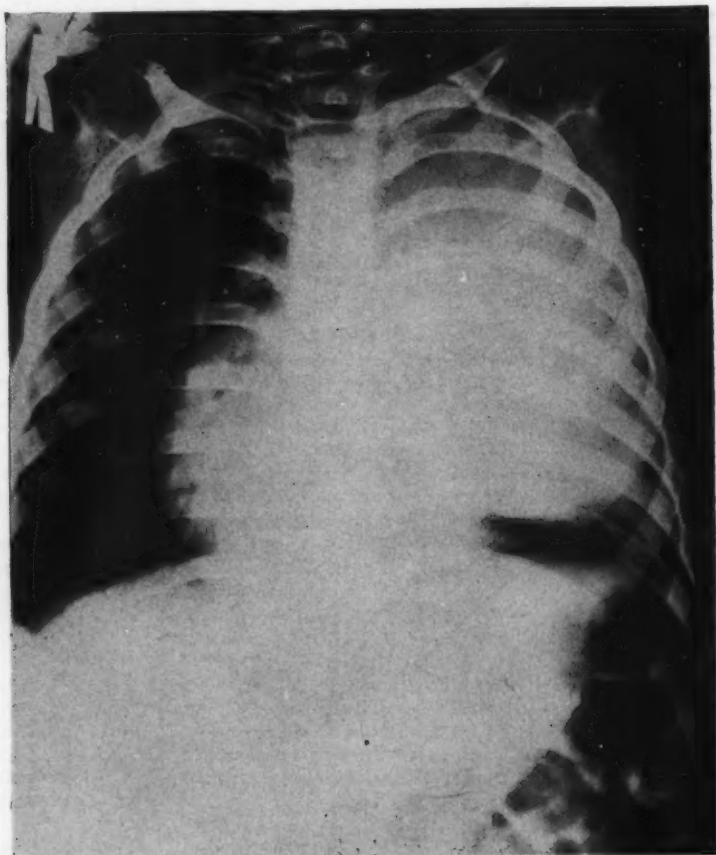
Preoperative x-ray of the chest. The giant-sized tumor almost fills the entire left chest. Note mediastinal shift to right.
